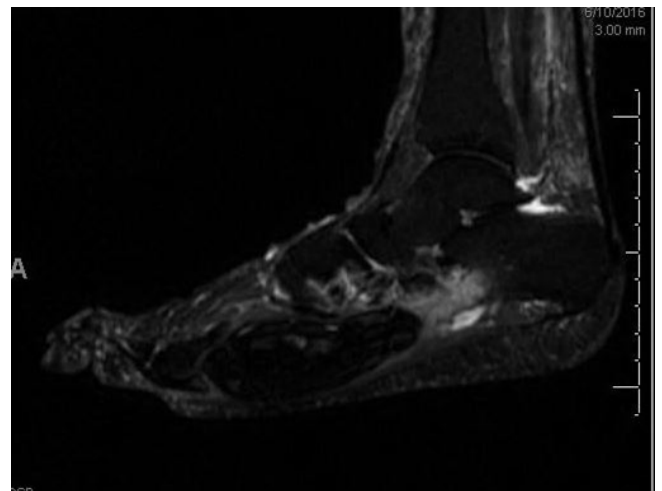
MRI sagittal view right foot.
